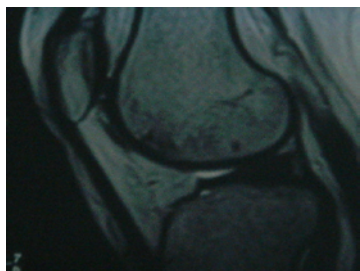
Coronal MRI of the same patient one year after surgery showing partial healing of the defect.
